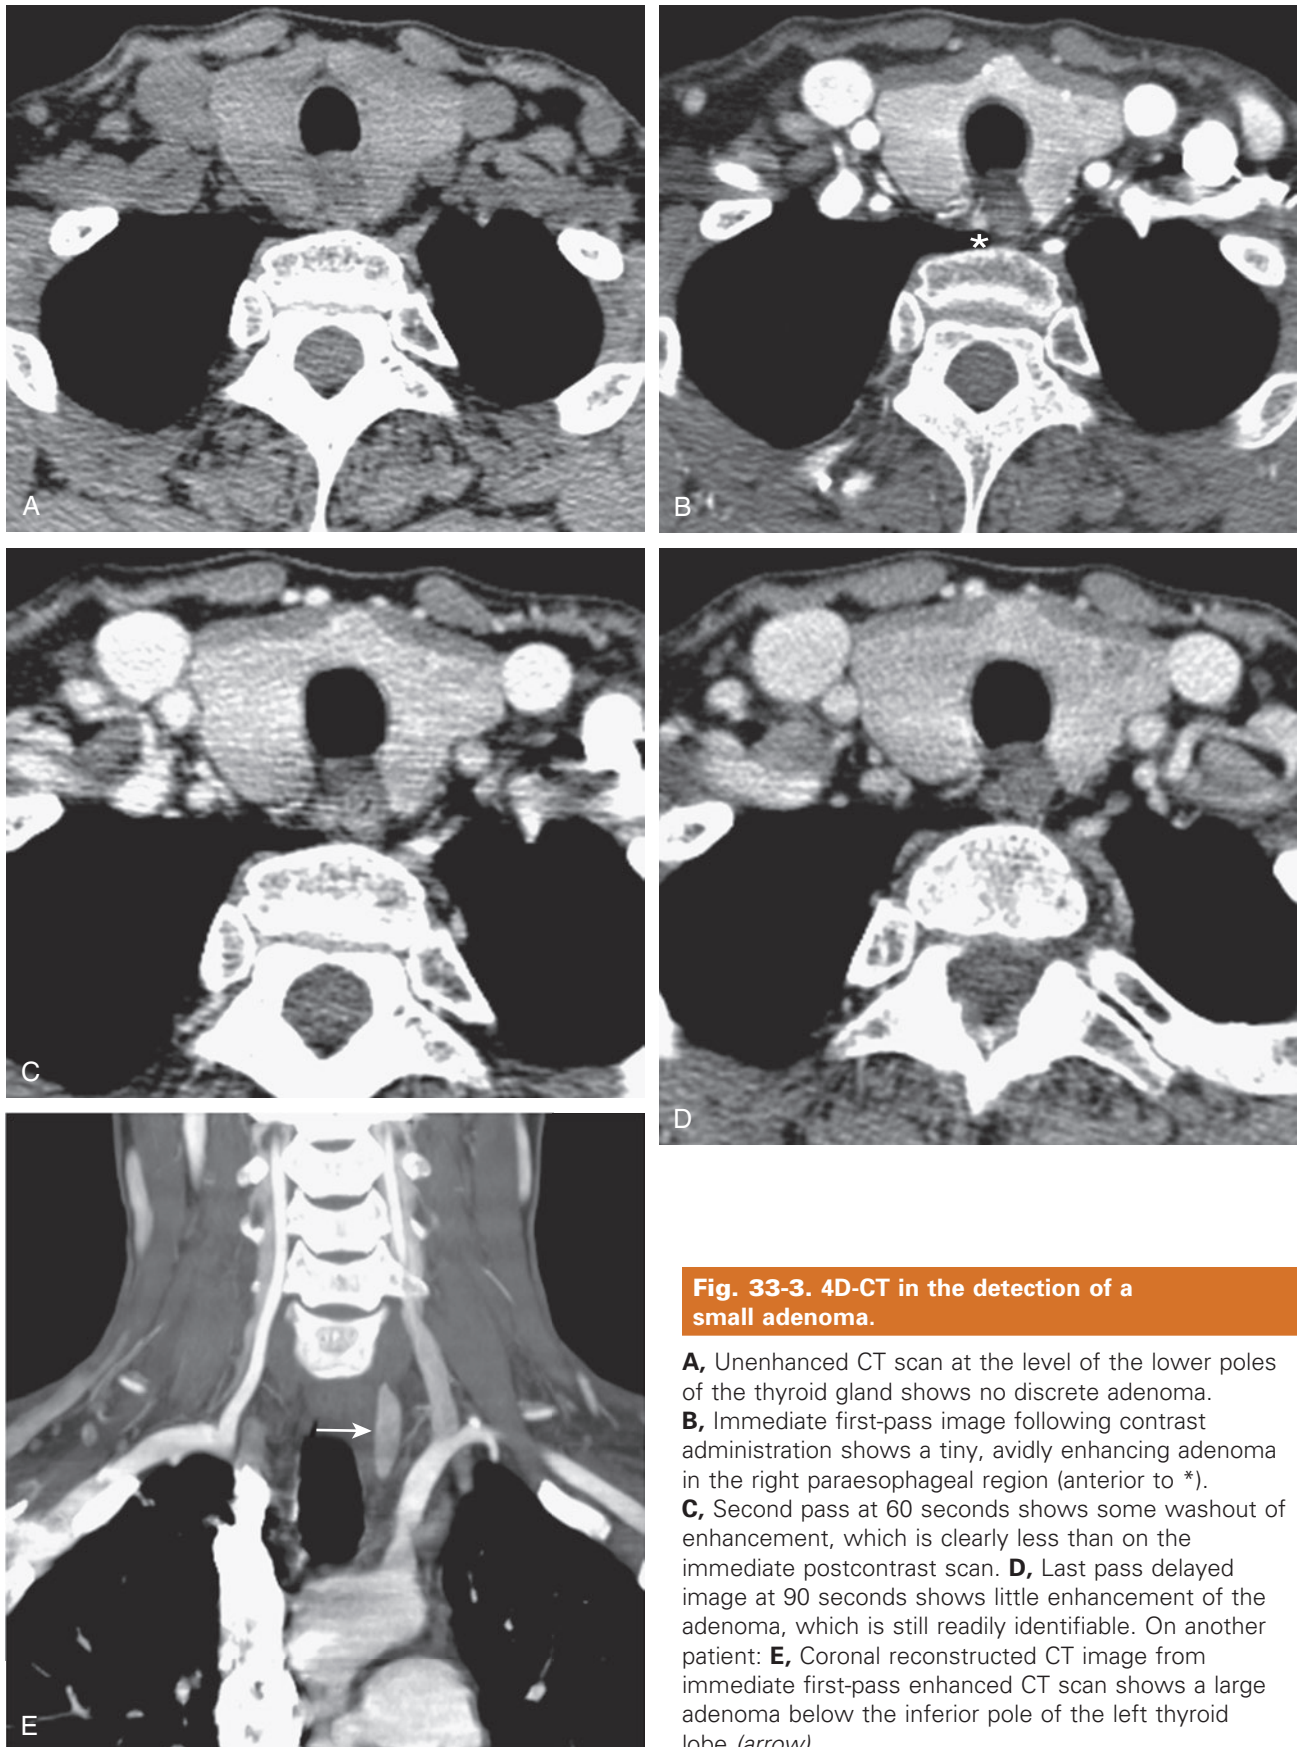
4D-CT in the detection of a small adenoma.
